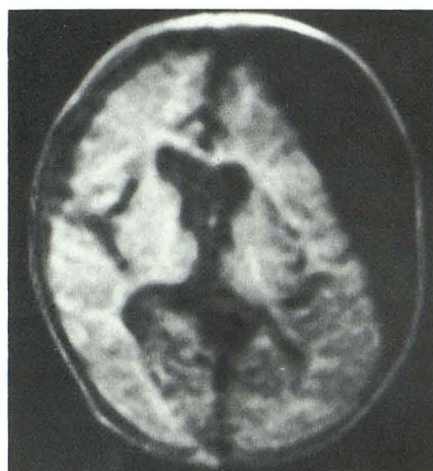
Inversion-recovery MR image (TI = 333/TR = 1545) of 15-month-old boy shows compression of left frontal horn and contralateral ventricular shift by the subdural collection.
